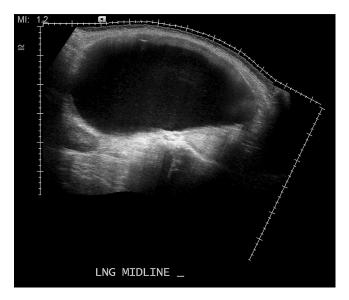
Sagittal transabdominal ultrasound image at the midline. There is a large cystic mass without mural nodularity or septations extending from the pelvis to the level of the left hepatic lobe.
